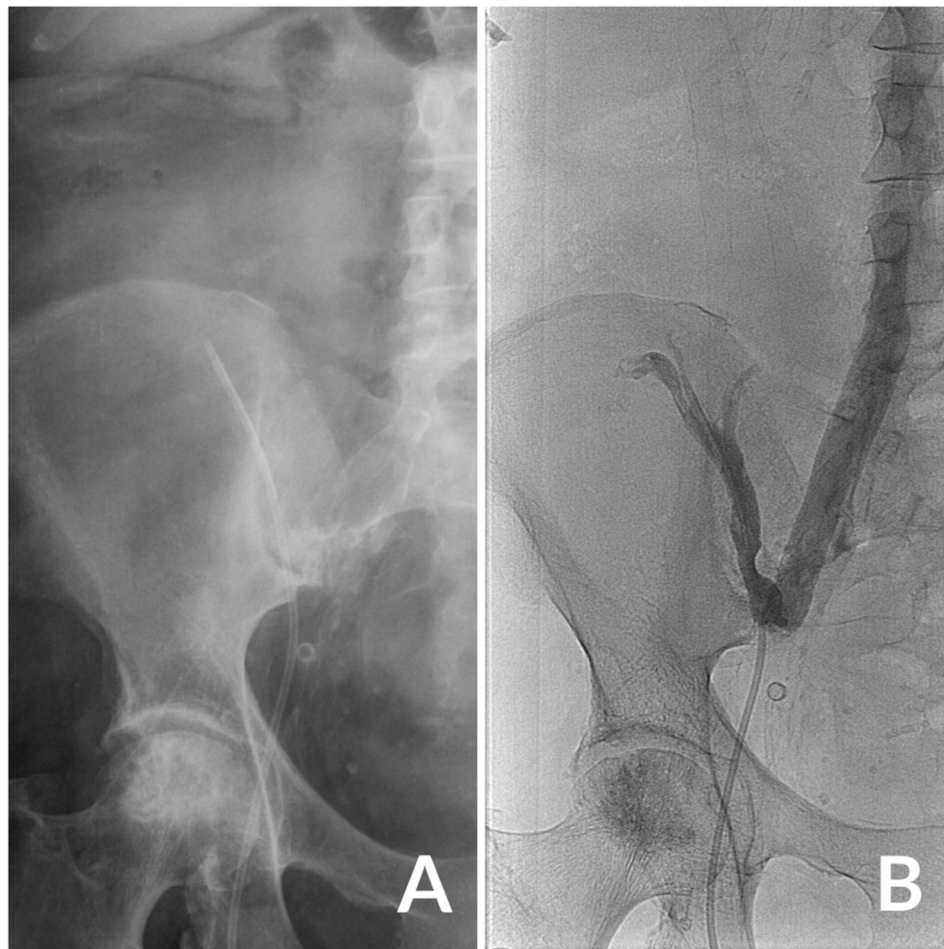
(A) Abdominal radiograph demonstrating catheter course toward the renal graft vein. (B) Venography confirmed that the final part of the catheter was positioned in the renal graft vein
